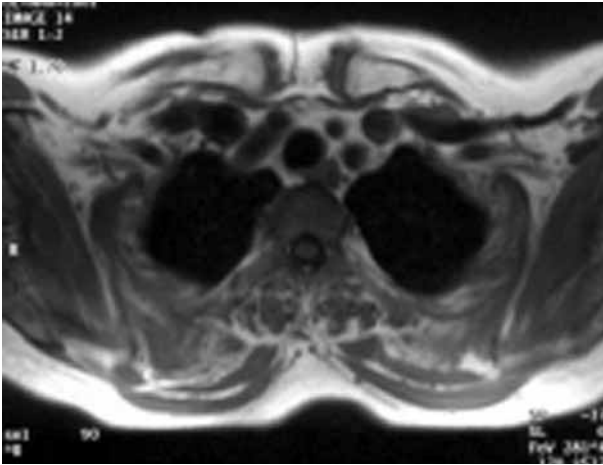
Axial MRI : T1-weighted image of the same patient demonstrating bilateral involvement of the subscapular soft tissue mass.
